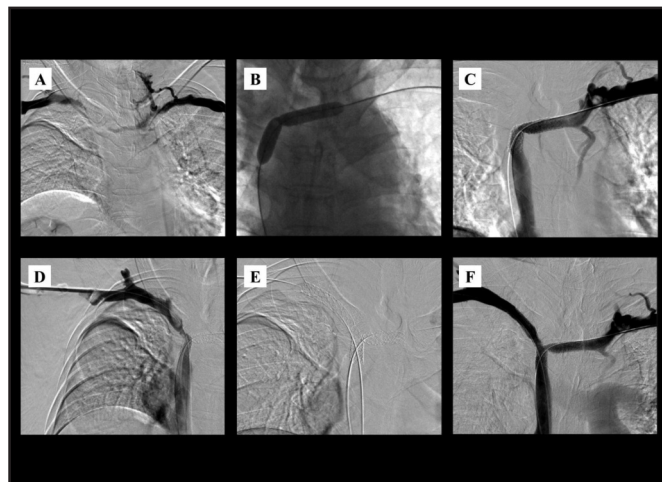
A Bilateral upper-extremity diagnostic venograms (Case 2) revealing complete occlusion of the SVC and both distal brachiocephalic veins with collateral vessels seen. Prior CT scan of the thorax showed compression of these vessels by metastatic lymph nodes. B A 0.035" Terumo J curved guide wire which was loaded in a 5 Fr Bern catheter was advanced through the left brachiocephalic vein and SVC into the right atrium via left basilic vein access. After the wire successfully crossed the stenotic lesion, the Terumo wire was exchanged with a 0.035" Bentson wire to provide better support. Subsequently, balloon angioplasty was performed to the left brachiocephalic vein extending into proximal SVC. The balloon was then inflated at nominal pressure to achieve optimal result. C Balloon-mounted stent was inserted and positioned in the left brachiocephalic vein extending to SVC. The stent was eventually deployed and post-dilated at nominal pressure with recanalisation of the left brachiocephalic vein and SVC seen. D Similar steps were repeated on the opposite side via right basilic vein access. The guide wire managed to cross the right brachiocephalic stenosis and was later negotiated through the first stent struts into the SVC. Balloon angioplasty was performed on the right brachiocephalic vein and SVC as well as creating fenestration on the first stent. E Balloon-mounted stent was inserted in the right brachiocephalic vein into the proximal SVC via the stent in stent approach, conforming to a Y-shaped stent. F Post stent deployment showing significant improvement in the lumen of both brachiocephalic veins and SVC with good blood flow into the right atrium.
